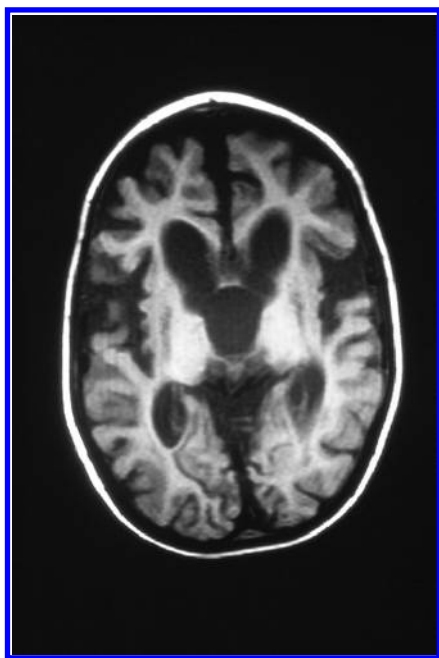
AA: Computed tomographic scan of the brain. There was considerable atrophy.
